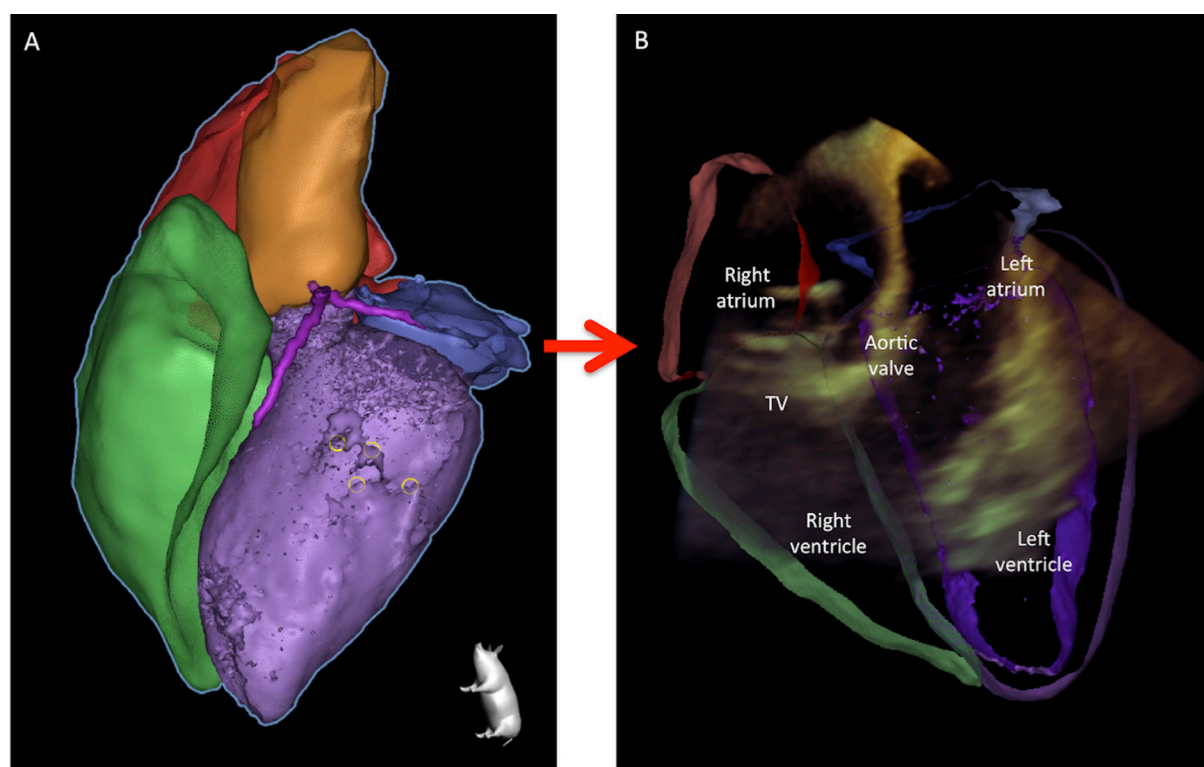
A glimpse into the future. Initial validation step of CT vs. Echo segmentation merged together in one image. TV: tricuspid valve
